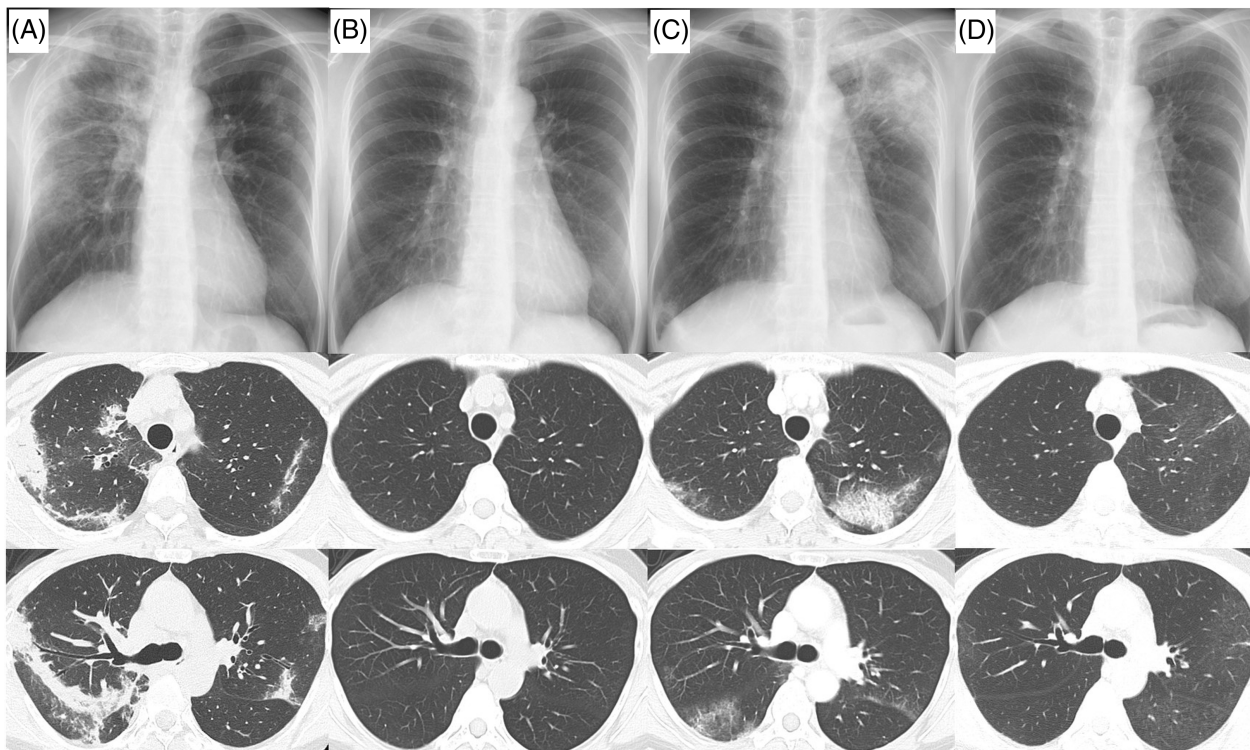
Computed tomography images of the chest (A) when developing eosinophilic pneumonia (EP) during abemaciclib combined with letrozole and goserelin treatment, (B) when EP improved, (C) during EP relapse after the discontinuation of prednisolone (PSL) and resumption of letrozole and goserelin, and (D) 2 weeks after the re-administration of PSL.
